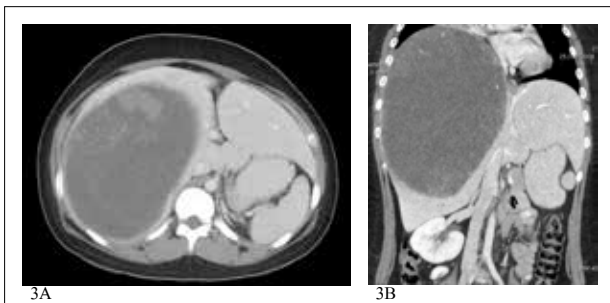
Axial and coronal reformatted CT images of the abdomen demonstrate a large hypodense mass in the right lobe of the liver. Focal hyperdensity was noted inside the mass.
